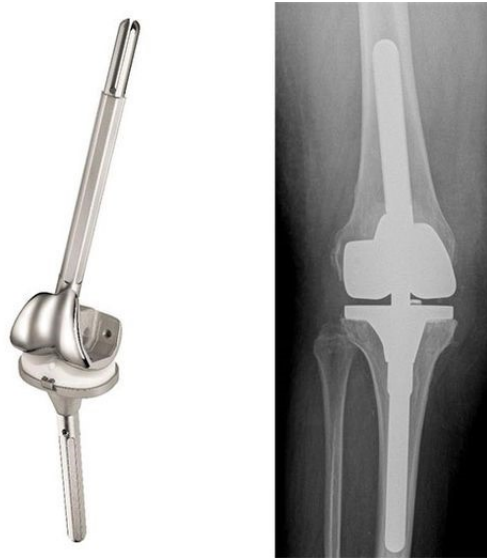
Hinged prosthesis model and radiography of the implanted hinged prosthesis [57]
